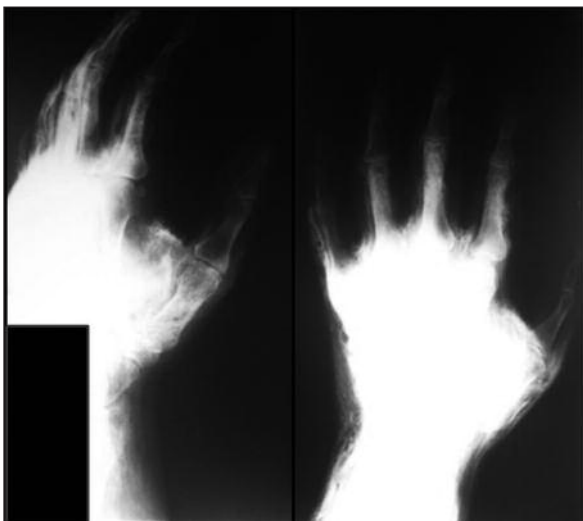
Antero-posterior and lateral radiographs of the right hand showing extravasation of contrast medium.
